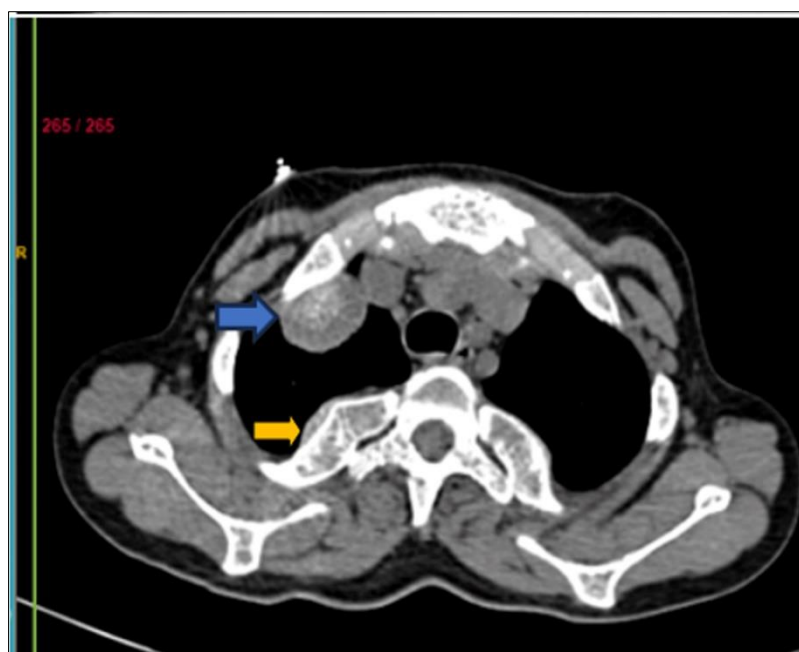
CT thorax axial section revealed diffusely expanded vertebrae (yellow arrow) and soft tissue mass (blue arrow) along the anterior end of the ribs
